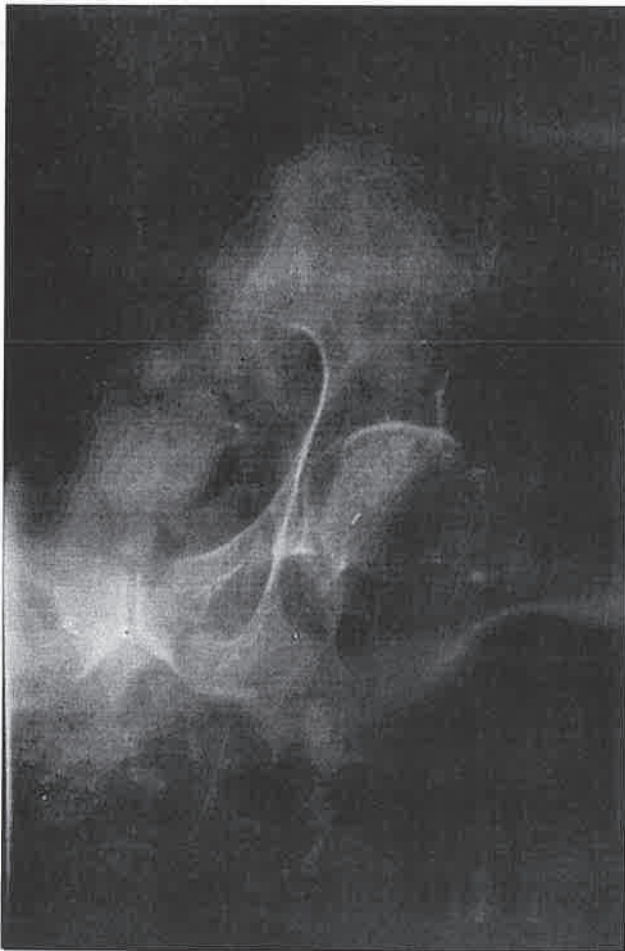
A: Preoperative radiograph of trochanteric fracture with an intact trochanter minor.
